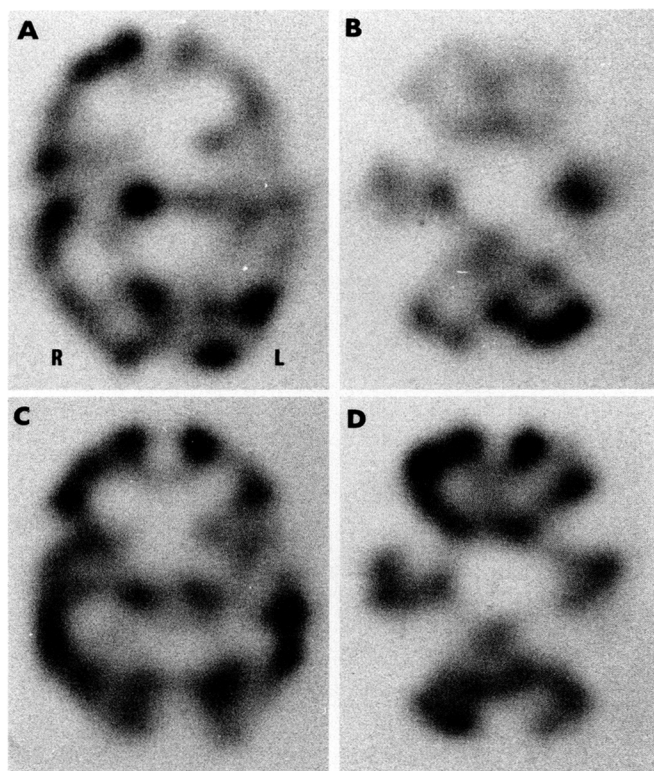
[ $^{123}\text{I}$ ]Isopropylidoamphetamine single-photon emission computed tomograms with (bottom) and without (top) acetazolamide infusion in patient 12. Without acetazolamide infusion, ipsilateral thalamic (A) and contralateral cerebellar (B) hypoperfusion is evident. After acetazolamide infusion, hypoperfusion in thalamus (C) and cerebellum (D) is lessened. R, right side of patient; L, left side of patient.
